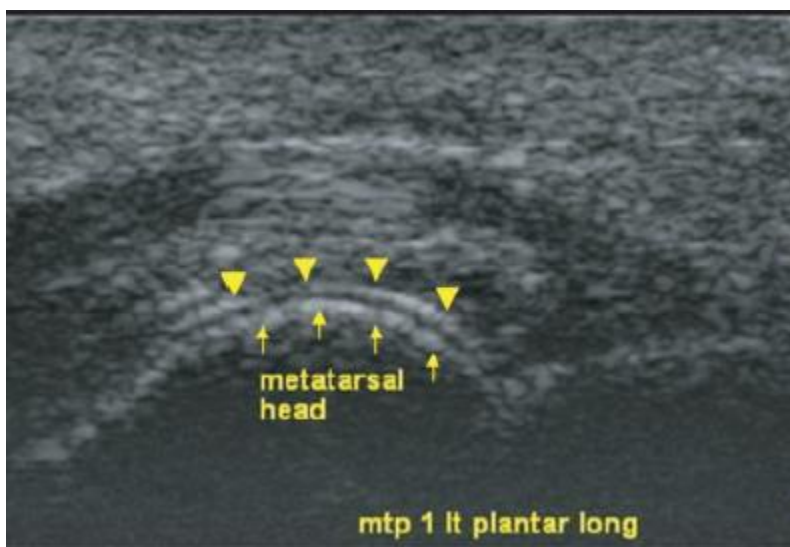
The double contour sign. From *Diagnosis of gout by ultrasound*, Thiele & Schlesinger (127). Reprinted with permission.
